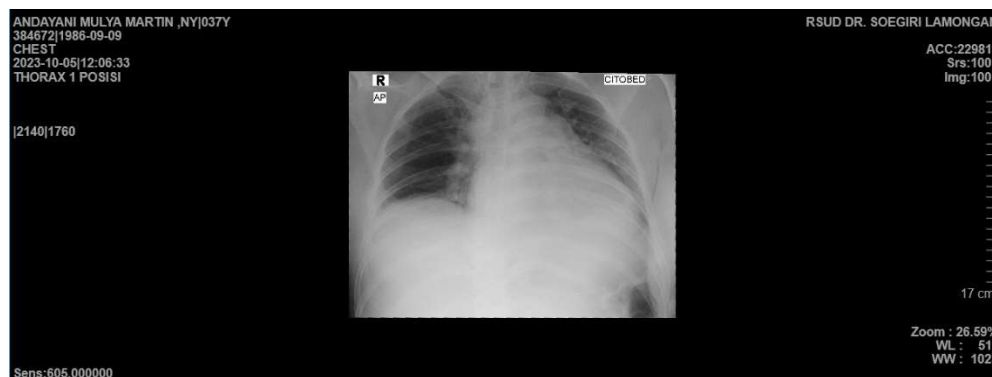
Chest X-ray results of a patient experiencing LV Concentric Remodeling (thickening of the left ventricle wall)
